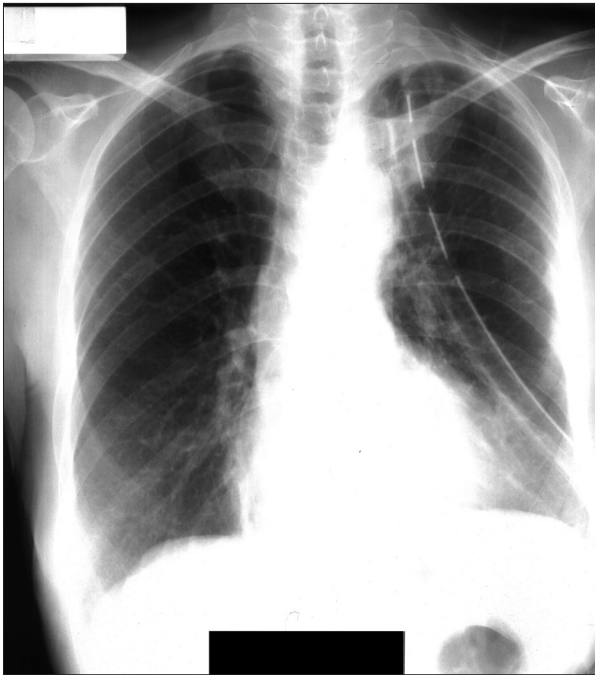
Normal chest-X-ray taken 3 days before discharge from hospital after re-evaluation and wedge resection of lung pseudotumor.
